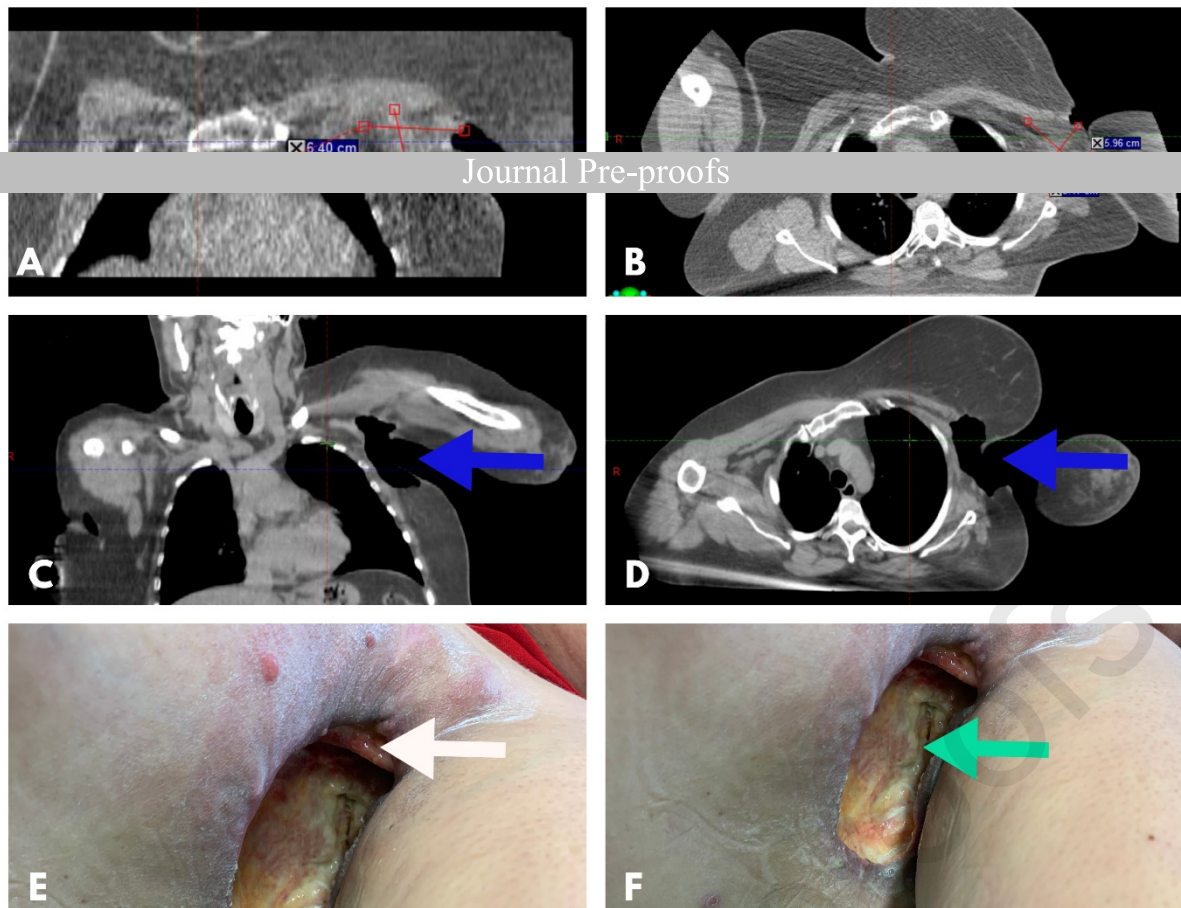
T3N1 epitheloid sarcoma of the left axilla. A, B: preECT coronal and axial CT showing tumor diameters; C, D: 2-month follow-up coronal and axial CT confirming partial response (blue arrows). [preECT tumour volume: 82.4 cm³ vs postECT tumour volume: 39.1 cm³; volume change: -52.55%]-non-contrast enhanced CT scan images. E: postECT image of left axilla with edge of pectoralis major muscle (white arrow), and F: cavity after necrotic tumour tissue removal. Plastic surgery- closure of cavity with advancement flap was planned, unfortunately the patient deceased prior to surgery. ECT: electrochemotherapy; CT: computed tomography
